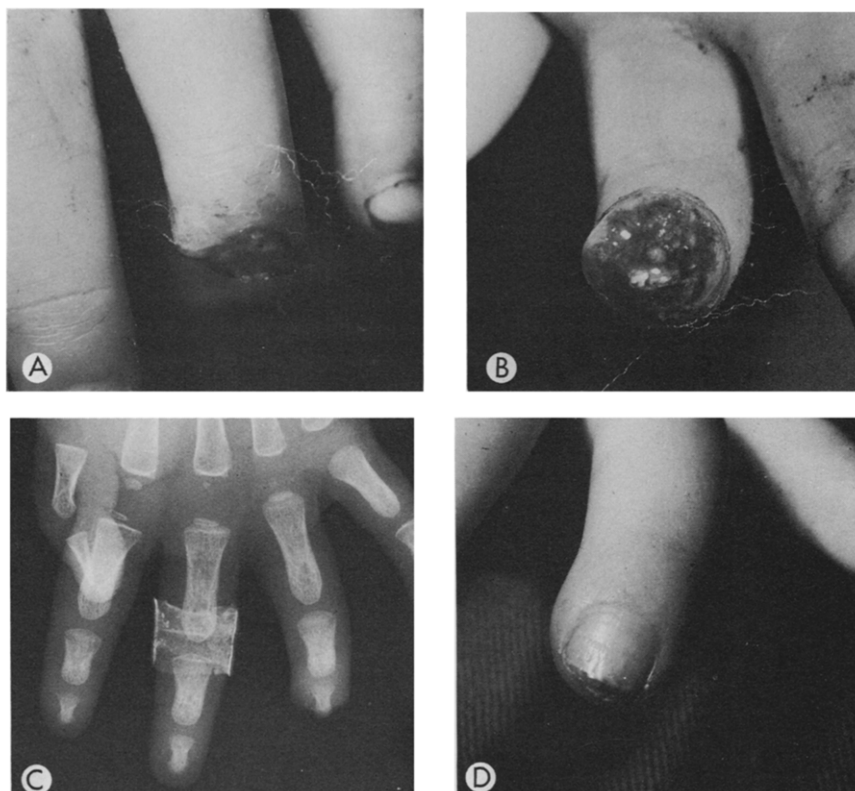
(A), (B) Guillotine amputation of finger tip in child of 1 yr 10 mo. (C) X-Ray. (D) Eleven weeks after accident.
